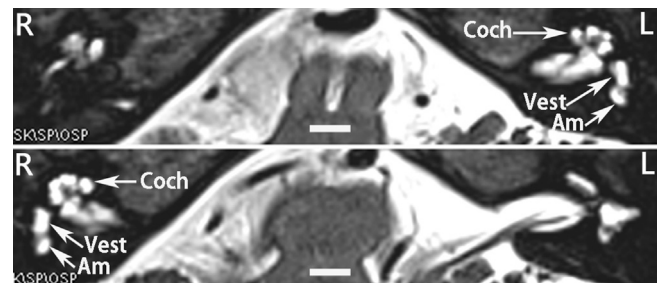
Heavy T2-weighted MRI of the inner ear in a patient with bilateral sensorineural hearing loss. All compartments of the inner ear on both sides are filled with fluids. Am: ampulla; Coch: cochlea; Vest: vestibule. Scale bars = 5 mm.
